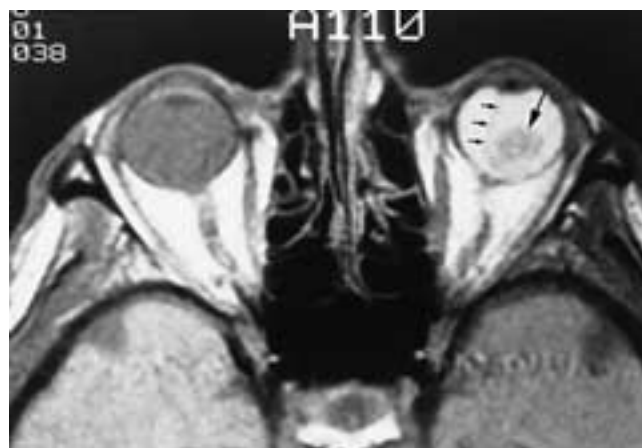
Total retinal detachment. Axial PW MR image shows a mass (*arrow*) with total retinal detachment (*arrows*). The subretinal exudate is hyperintense.
